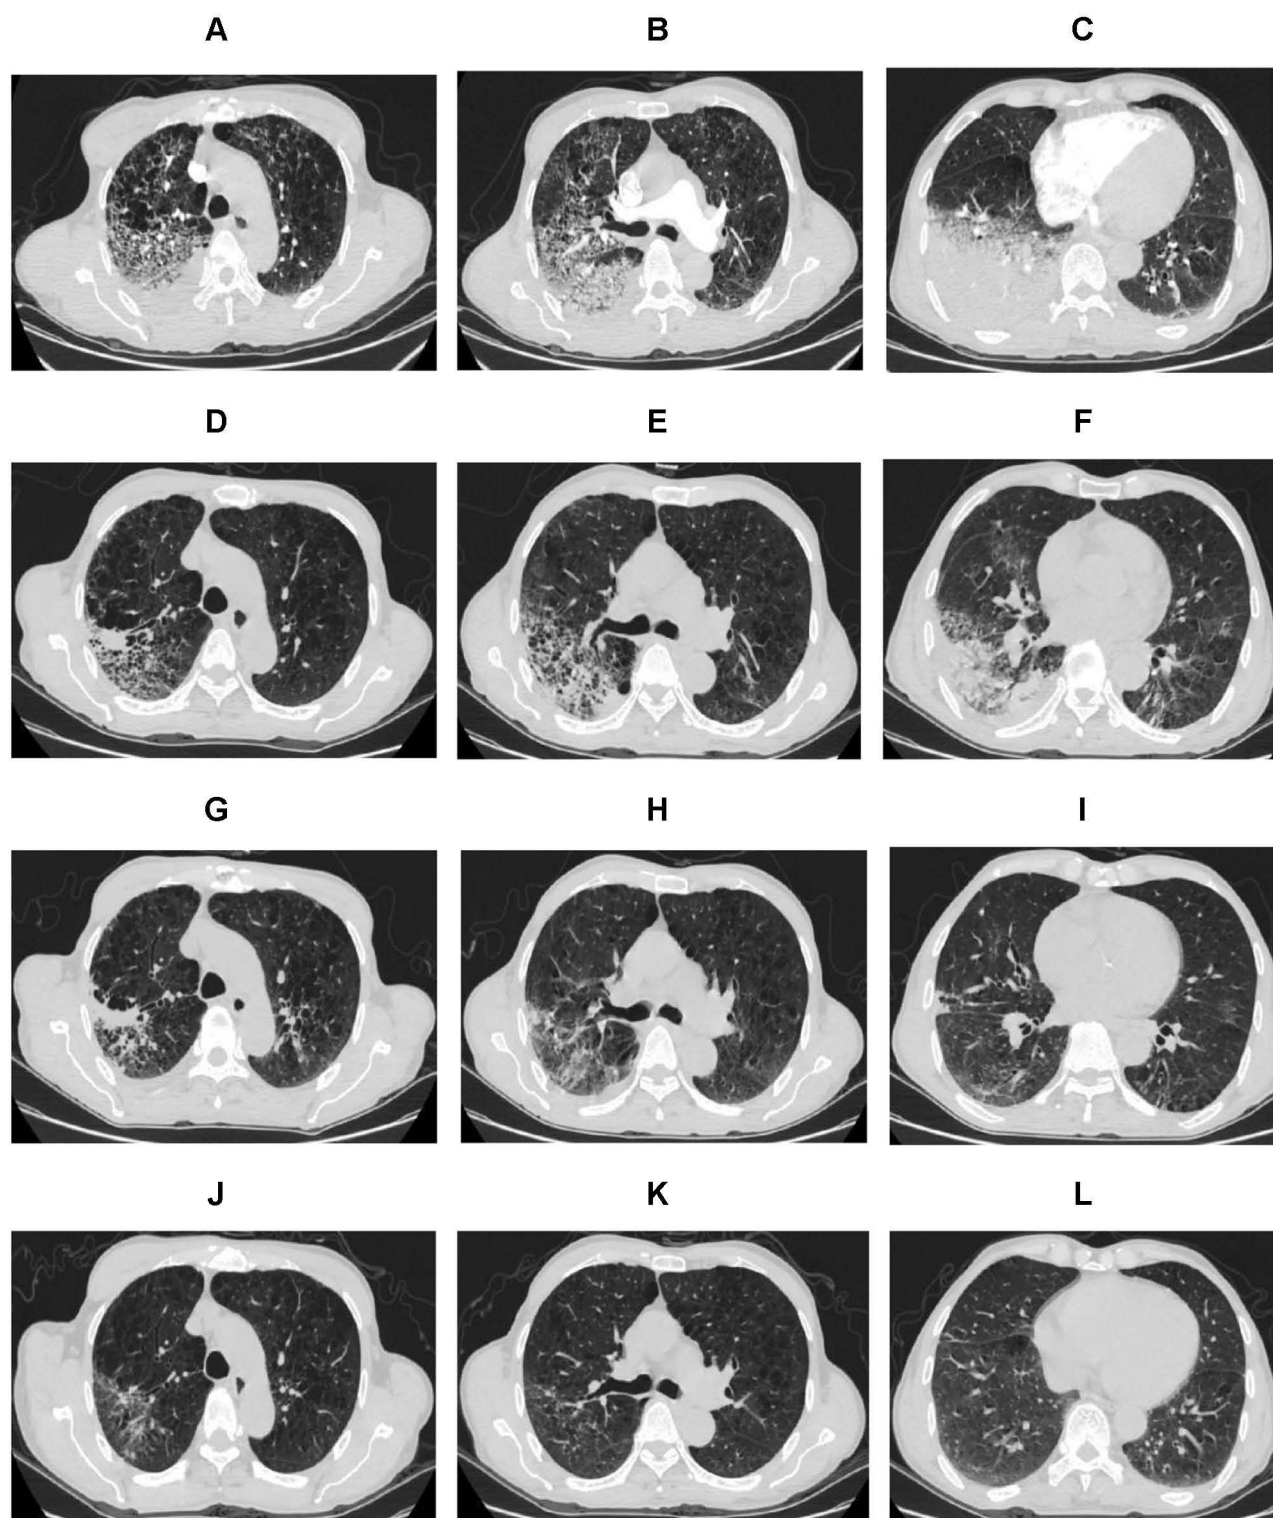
Chest CT findings of Severe *Chlamydia psittaci* pneumonia. (A–C) March 2, 2022: The day of admission. Large exudative foci in the right lung and a large consolidation shadow in the right lower lung. (D–F) Thirteen day after admission on March 15, 2022. Exudative foci and consolidation shadow in the right lung were less pronounced than those before. (G–I) Twenty-two day after admission on March 24, 2022. Further resorption of the right lung lesion than before. (J–L) April 24, 2022: 1 month after discharge. The lung lesions were largely resorbed, leaving only a small number of fibrous linear opacities.
